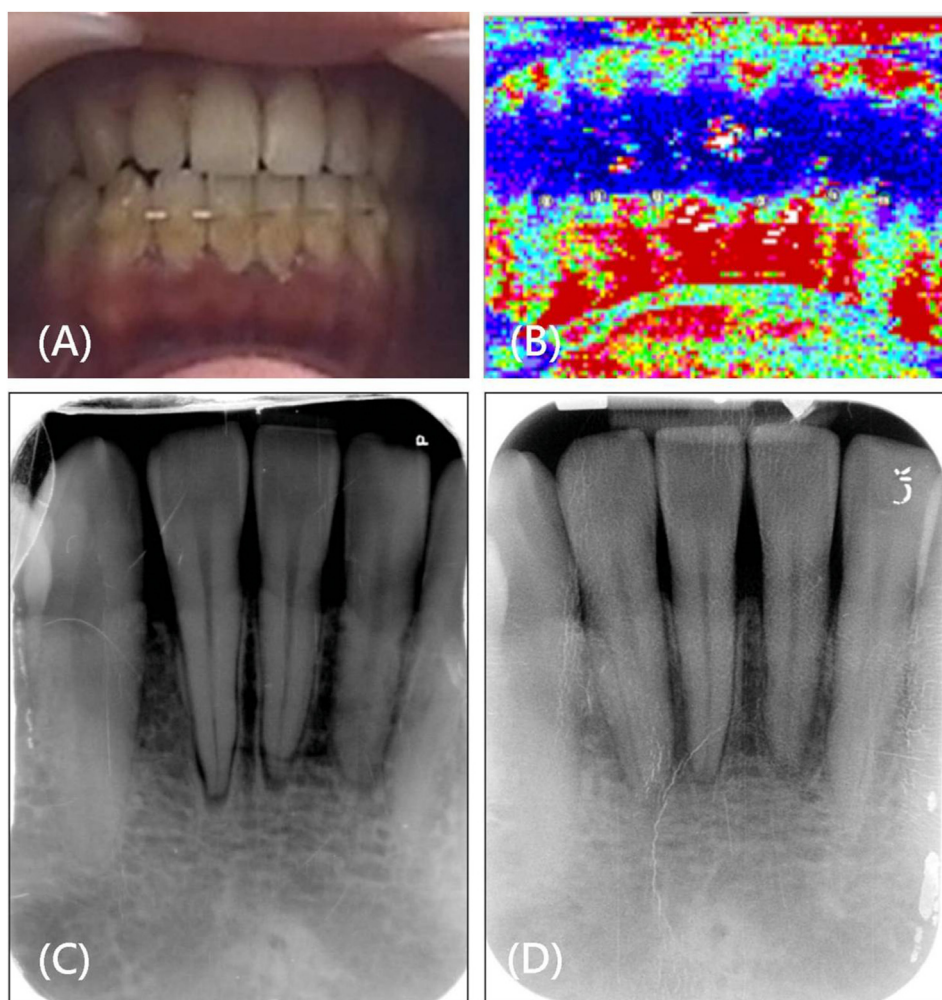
Clinical case presentation. (A) Clinical photograph: there is no response to the electrical pulp test of the mandibular anterior teeth without any symptoms. (B) Laser Doppler imager shows normal blood flow of the lower anterior teeth. Therefore, we advised the patient to postpone root canal therapy (C) Preoperative X-ray showed the root fracture of tooth 31 at the apical third. (D) Follow-up X-ray after three months: the electrical pulp test of tooth 31 still showed no response, but the improvement of the lesion can be observed from the follow-up X-ray, and the root fracture was repaired after angiogenesis.
